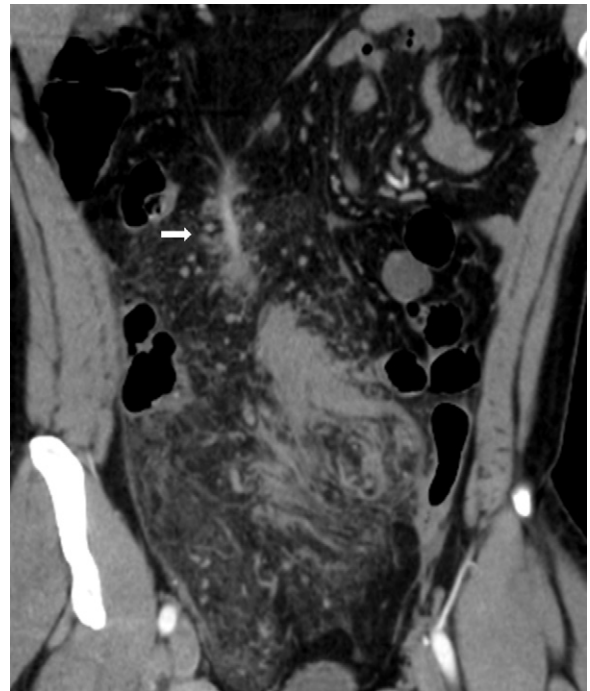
CT MPR images demonstrate the entire greater omentum from the pedicle to the most necrotic lesions of the greater omentum (arrow).
